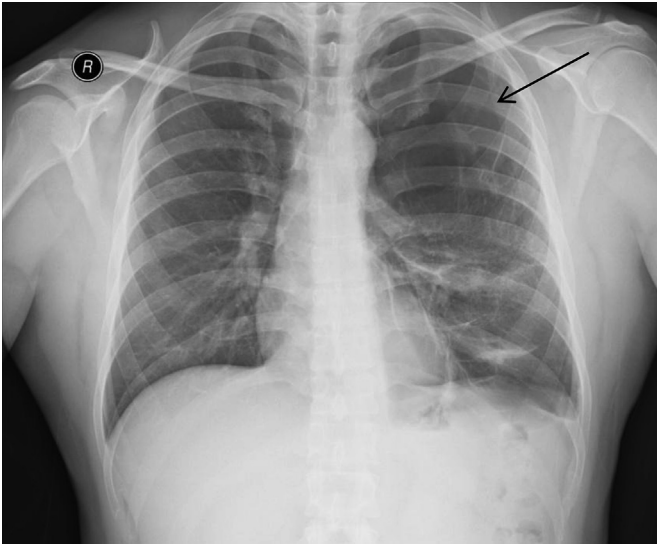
Chest radiograph – increased lucency (arrow) in left upper zone, with increased interstitial markings in left lower zone.
